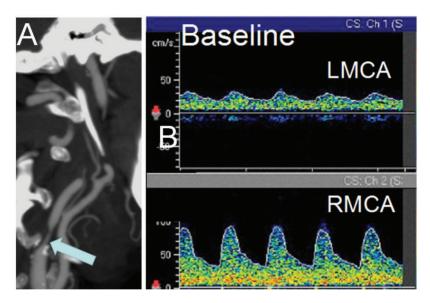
Preoperative CT angiogram and TCD findings.
